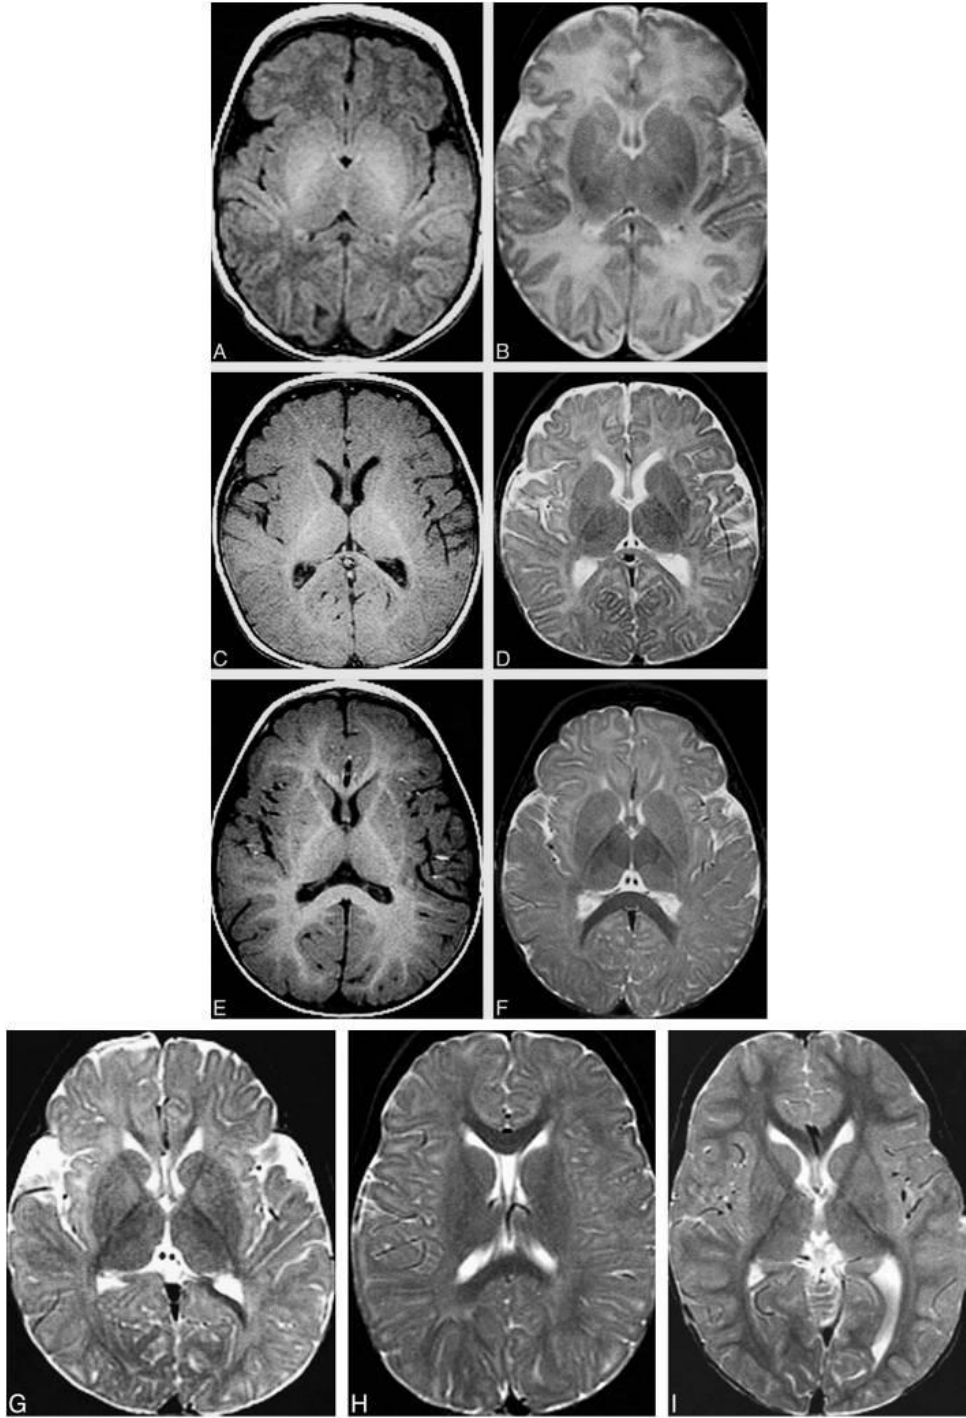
MRI changes of a normal pattern of myelination at the level of the basal ganglia. (A, B) Neonate MRI shows that myelination on T1-weighted image (A) and T2-weighted images (B) is limited to the posterior limb of the internal capsule at this level (black arrow). (B) Same patient shown in panel A. (C, D) of a 5-month-old patient shows hyperintensity in the entire internal capsule, optic radiations, and splenium of the corpus callosum. (D) Same patient shown in panel C shows hypointensity limited to the posterior limb of the internal capsule and a portion of the optic radiations. (E, F) 8-month-old patient shows hyperintensity in all white matter except the immediate subcortical regions. (F) Same patient shown in panel (E) shows hypointensity in the entire corpus callosum, the entire posterior limb of the internal capsule, and part of the anterior limb of the internal capsule. (G) 12-month-old patient shows hypointensity in the entire internal capsule, in the subcortical white matter of the motor cortex, and in the subcortical white matter of the visual cortex. (H) 18-month-old patient shows hypointensity in most of the deep white matter but lack of maturity of subcortical white matter. (I) Image of a 24-month-old patient show that essentially all white matter is hypointense. (Barkovich, 2000)
